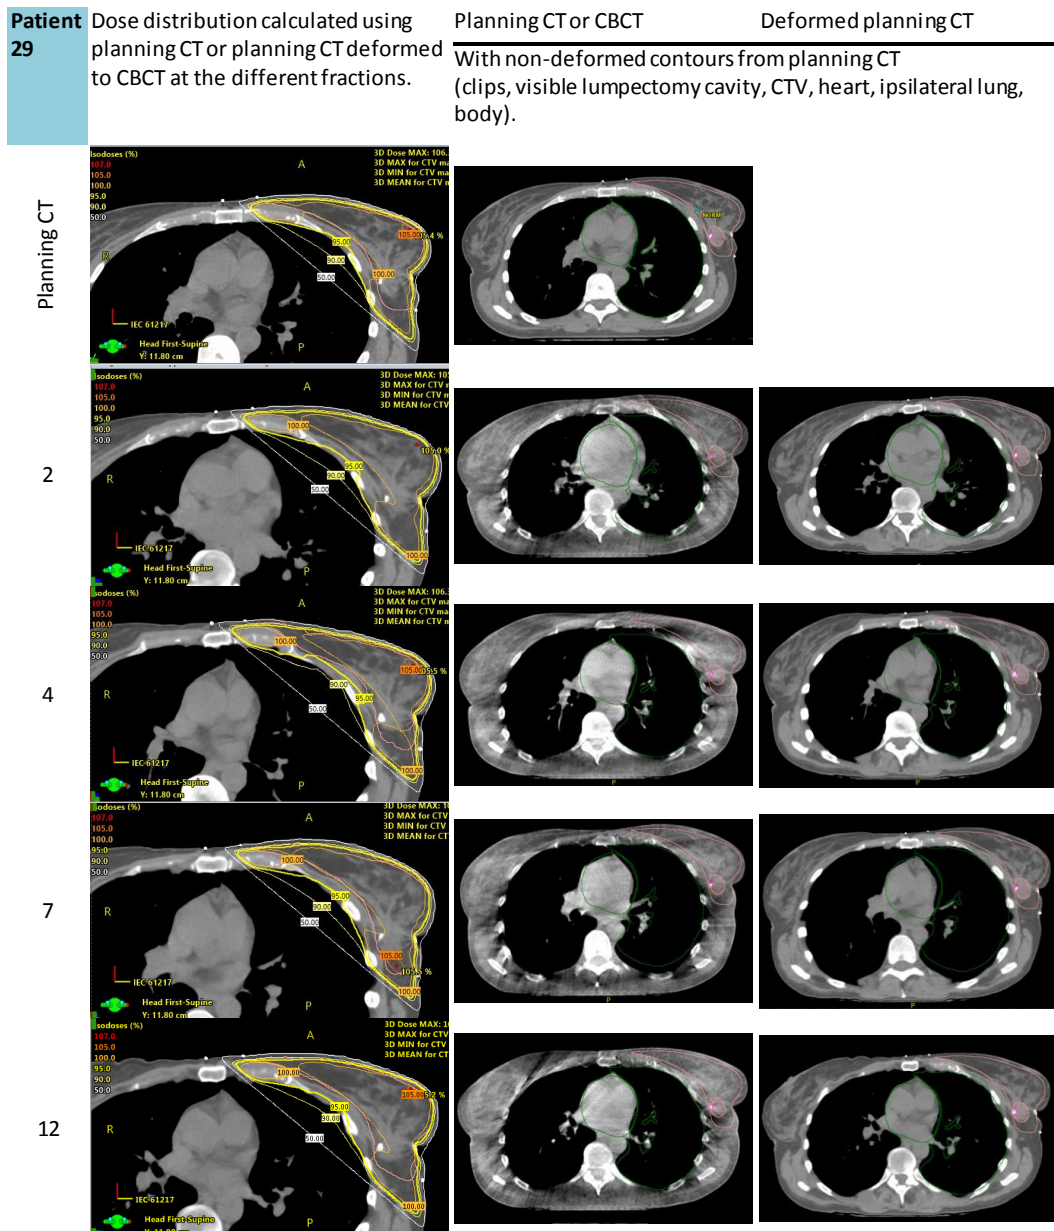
The dose distributions calculated on the original planning CT and the planning CT deformed to the CBCT acquired at fraction 2, 7, and 12. Patient 29.
